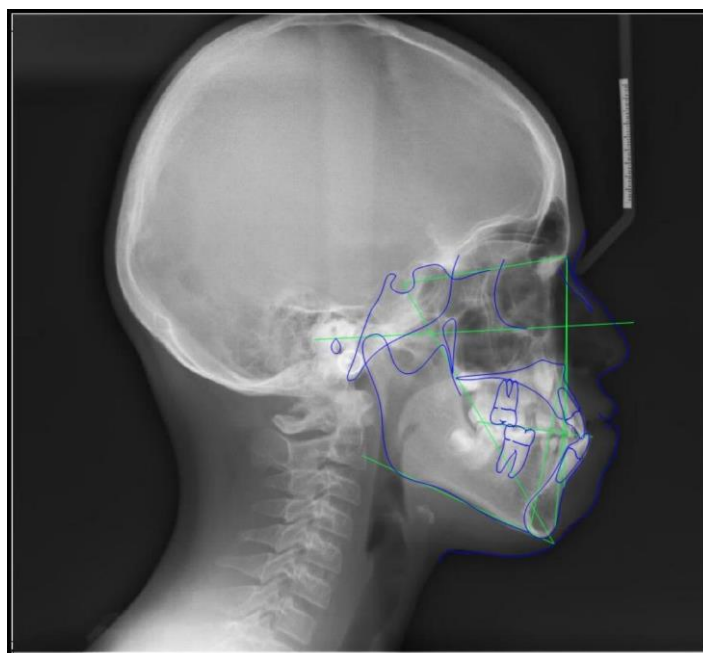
Pretreatment lateral cephalometric radiograph with tracing (T0).
